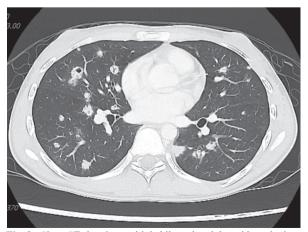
Chest CT showing multiple bilateral nodules with cavitation.
